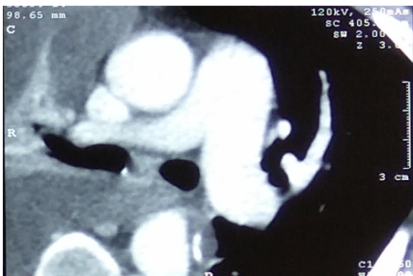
Axial CT view showing the dissection of the descending thoracic aorta.
